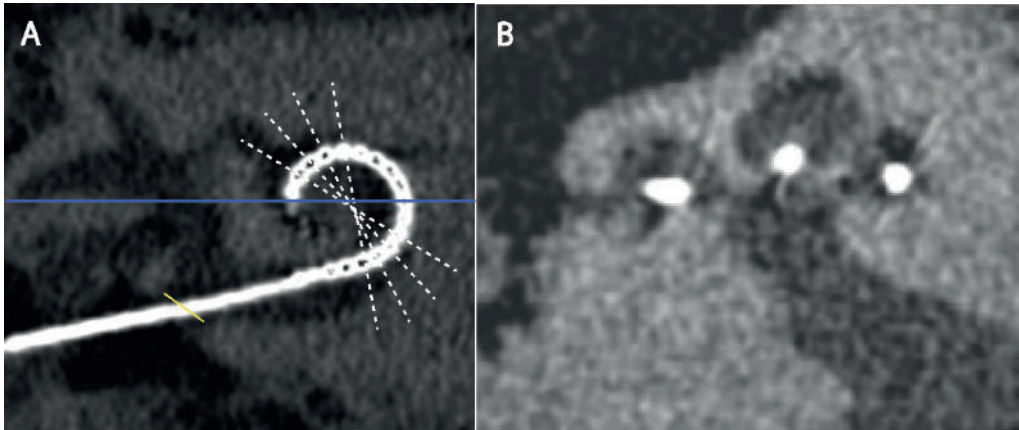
Methods for CT assessment: An oblique multi-planar reconstruction (MPR) through the basal turn of the cochlea was made (A) and mid-modiolar slices were obtained (B) with radial MPRs through the center of the cochlea (white lines in A). On such mid-modiolar images the presence or absence of NBF and the scalar position was assessed at each electrode contact. Angular insertion depth was measured from the top of the horizontal semicircular canal (blue line), using a correction factor to the center of the round window (yellow line) of 34 degree.[21, 22]
